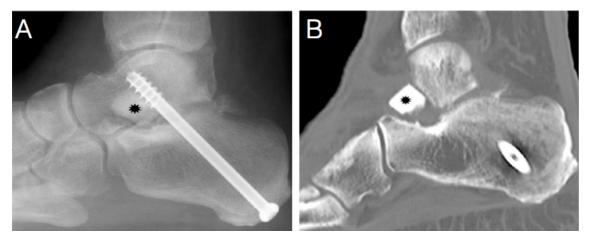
Extrusion of a cortical allograft and failure of fusion in a 61-year-old woman. Panel A: Lateral radiograph of the right foot, obtained 9 months after graft placement, shows the bone graft (*) and a screw bridging the subtalar joint fragments. Panel B: Sagittal reconstruction CT image, obtained 4 days after 'A', shows extrusion of the bone graft (*) into the sinus tarsi and persistence of the subtalar joint fracture, with no osseous union. Figure and legend are adaptation from reference 80.
